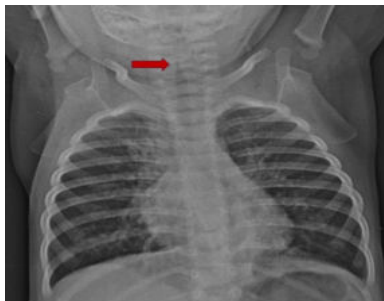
Xray depicting the steeple sign (arrow) representing subglottic stenosis in croup.
